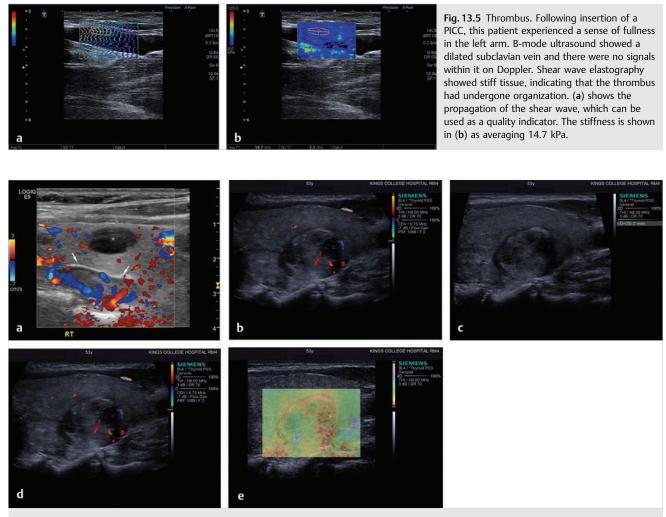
Parathyroid gland. An encapsulated, hypervascular nodule (*arrows* in a) lying deep to the lower pole of the right lobe of the thyroid is seen in this patient with hypercalcemia; on strain elastography (b), it had intermediate signals, perhaps slightly less stiff than the adjacent thyroid. Its capsule shows as a stiff (blue) region, in keeping with its fibrous nature. There is also an incidental thyroid cyst (*asterisk* in a), which showed the typical blue-green-red artifact given by fluid. The 15 mm nodule indenting the posterior surface of the right lobe of the thyroid gland in (c) had a heterogeneous texture and was moderately vascular on Doppler (d). On strain elastography (e), it had a mixed pattern, with extensive stiff regions (coded in red), which is unexpected for a simple parathyroid adenoma. It proved to a parathyroid carcinoma on biopsy and subsequent excision. ([a, b] Courtesy of Dr. Chris Harvey, Hammersmith Hospital, Imperial College, London. [c, d, e] Courtesy of Prof. Paul Sidhu, King's College Hospital, London, UK.)
